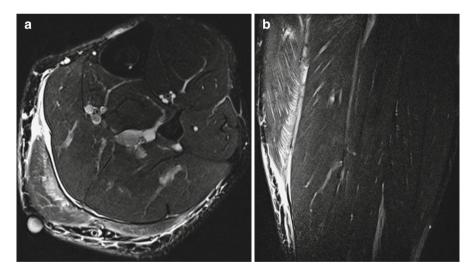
Axial (a) and sagittal (b) MR images of a partial avulsion of the gastrocnemius muscle (medial head). Note the extension of edema along the fascial planes (grade 2 injury) (Reprinted with permission of Thieme [25])
